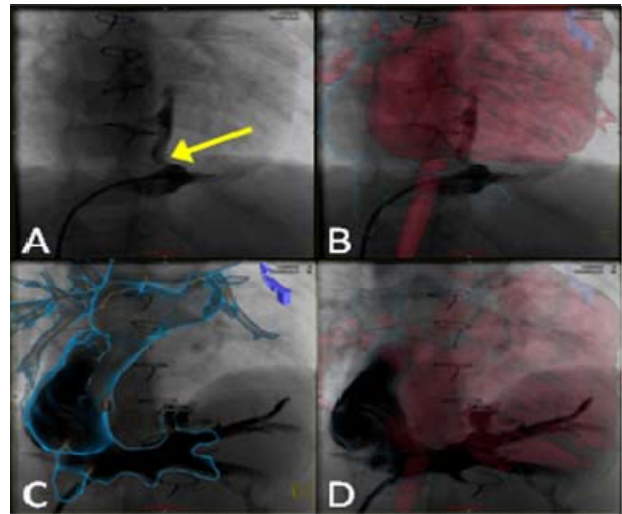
Clinical XMRF A) X-ray image of the residual left hepatic vein to atrium connection (yellow arrow). B) Addition of the MRI overlay of the right heart in blue and the left heart in red, showing the flow from the hepatic into the atrium. C,D) XMRF images acquired after an 8mm Amplatzer plug was seated in the connection, showing no residual flow into the atrium.
